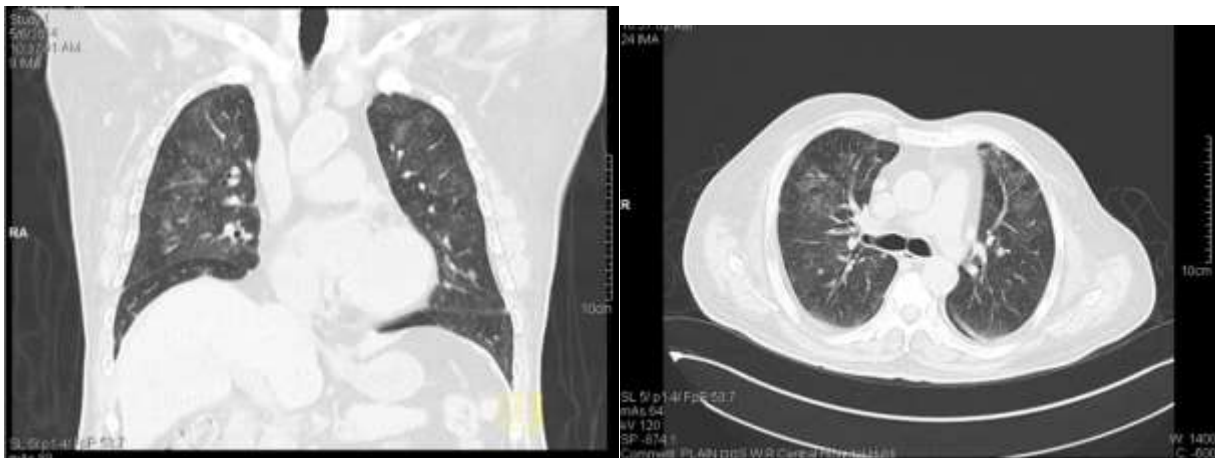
CT scan showing bilateral ground glass opacities with homogenous coin lesions, suggestive of metastasis
